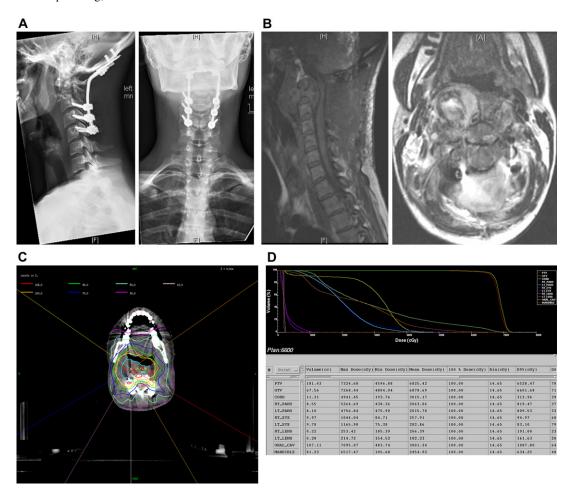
A 33-year-old woman, 27 weeks pregnant, with no precedent history tripped on an airplane tarmac. She had the acute onset of central cord syndrome with plegia of the upper extremities. MRI showed a tumor replacing the C2 body with high-grade spinal cord compression and a large parapharyngeal mass. (A) Patient was taken urgently to surgery for posterolateral decompression of the tumor and posterior occipital-to-C5 fixation. The patient had immediate return of neurologic function, with the exception of persistent paresthesias in the hands. Pathologic findings were consistent with leiomyosarcoma, estrogen receptor- and progesterone receptor-positive, and suspected uterine origin. (B) Postoperative sagittal and axial MRI scans show sufficient epidural decompression to provide a safety margin for IGRT. Myelography/CT for IGRT planning confirmed the absence of spinal cord compression. The baby was delivered at 33 weeks of gestation without incident. Systemic workup after delivery showed lytic pelvic lesions and small lung metastases. A transmandibular approach was contemplated, but the decision was made to irradiate with high-dose conformal photons using standard fraction radiotherapy (66 Gy in 37 fractions). (C) Dose distribution through the isocenter of a large leiomyosarcoma (67.5 cc) involved C2 to C5 with a significant paraspinal component. A total of seven beams of 6-MV photons were used around a single isocenter to deliver the prescribed dose of 66 Gy given to the 100% isodose line. The combination of intensity-modulated radiotherapy and near-real-time image-guided techniques allowed a relatively high dose of radiation to the tumor while maintaining less than 50 Gy to the spinal cord. (D) Dose volume histogram of the treatment. Excellent coverage of the gross tumor volume (GTV; blue outline) and planning target volume (PTV; vellow outline) was achieved while sparing nearby surrounding dose-sensitive structures, such as the spinal cord (maximum dose of 49.4 Gy) and parotid glands (mean dose <21 Gy).
